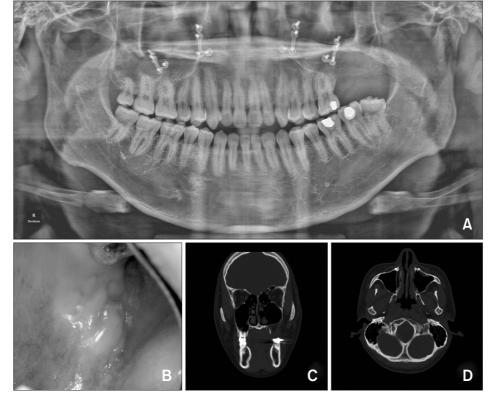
(A) Follow-up panoramic radiograph obtained 3 months postoperatively. No bony healing was observed but the left sinus haziness appears to have been resolved. (B) Follow-up intraoral photograph obtained 1 month postoperatively. The perforated mucosa covered with the pedicled buccal fat pad shows good healing without a fistula. (C, D) Followup computed tomography scans in the coronal and axial views obtained 3 months postoperatively. No signs of recurrence was observed.
